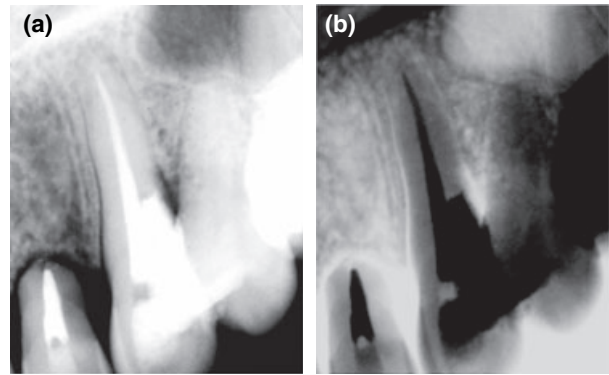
(a) Radiographic control – 2 years. (b) Negative view.
